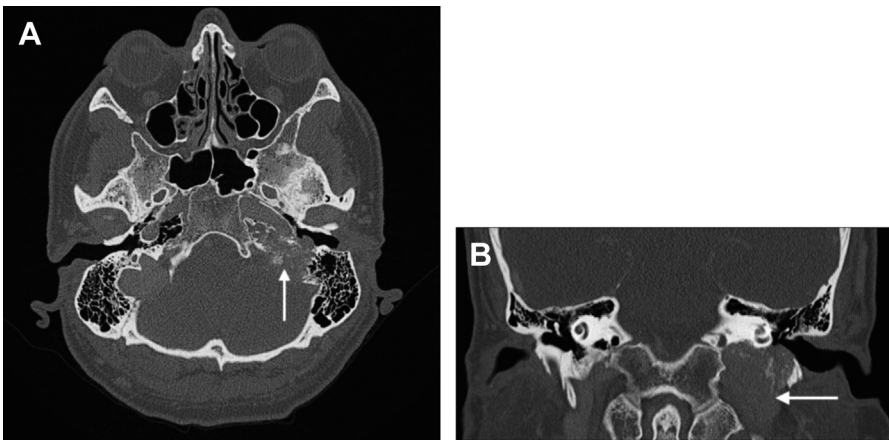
High-resolution CT demonstrating the expected growth pattern of a GJT relative to the bone of the lateral skull base. The white arrow designates an area of tumor-associated bony destruction. (A) is an axial cut; (B) is a coronal cut.
